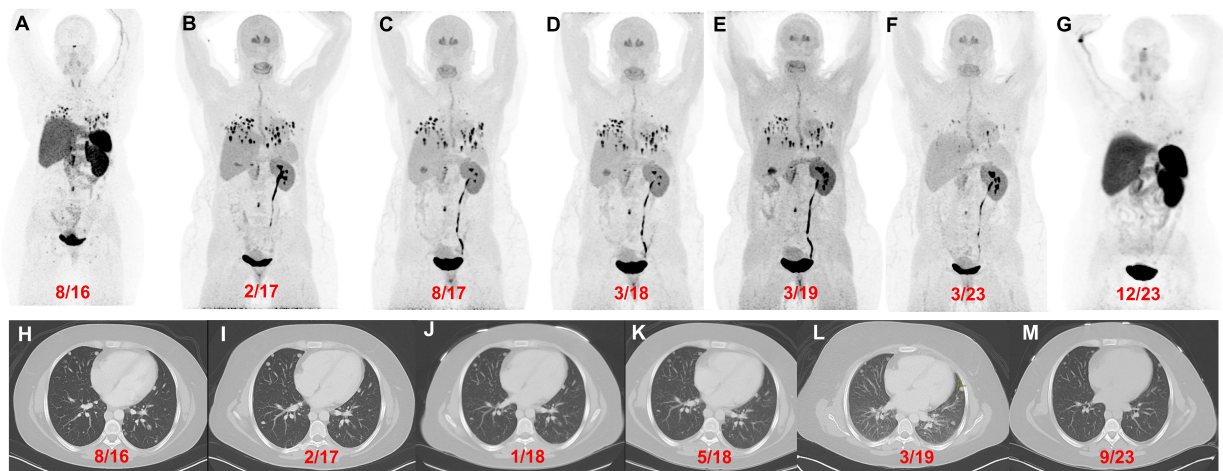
Patient 3 (26-year-old female, *VHL* pathogenic variant), serial images throughout the course of treatment: Anterior maximum intensity projection images of ^{68}Ga -DOTATATE PET/CT (A and G) and ^{18}F -FDOPA PET/CT (B–F) with a history of a right adrenalectomy (4.2 cm), right nephrectomy, and left periaortic- and aortocaval mass resection in 2016 [resection(s) prior to imaging] demonstrate widespread metastatic lesions in the lungs, retroperitoneal adenopathy, and a few bone metastases. ^{18}F -FDOPA PET/CT images before (B), during (C), and after (D) treatment with CAPTEM. ^{18}F -FDOPA PET/CT (E and F) imaging demonstrate disease stability with temozolomide monotherapy. ^{18}F -FDOPA PET/CT on 03/2023 (F) shows a significant decrease in the number of lung lesions and a reduction in tumor volume compared to prior imaging. The axial contrast CT images (H–M) in the same plane at various time points (08/2016, 02/2017, 01/2018, 05/2018, 03/2019, and 09/2023) show progression of disease prior to chemotherapy (H and I) followed by stable disease (J–L) and a marginal decrease in tumor size(s) on 09/2023 (compared to 03/2019). However, a more robust response was appreciated on ^{18}F -FDOPA PET/CT [02/2017 (B) vs 03/2023 (F)] and ^{68}Ga -DOTATATE PET/CT [08/2016 (A) vs 12/2023 (G)]
